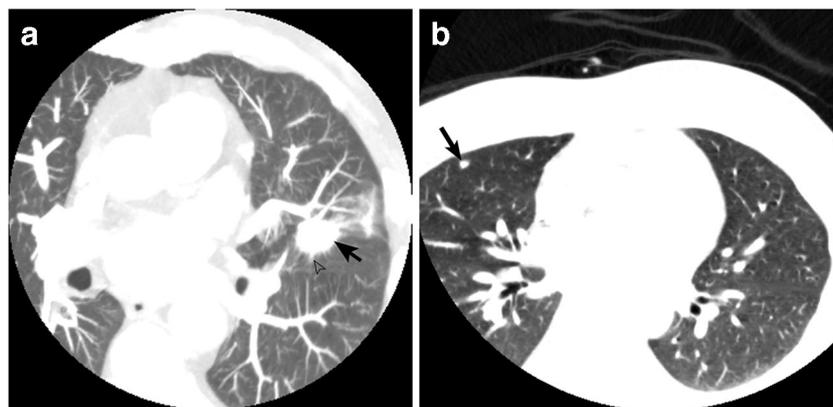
a Axial maximum intensity projection image from coronary CT angiography showing an incidental solid nodule (arrow) with spiculated contours (open arrowhead) in the left lung, proven to be a primary adenocarcinoma. b Axial image from coronary calcium score study
